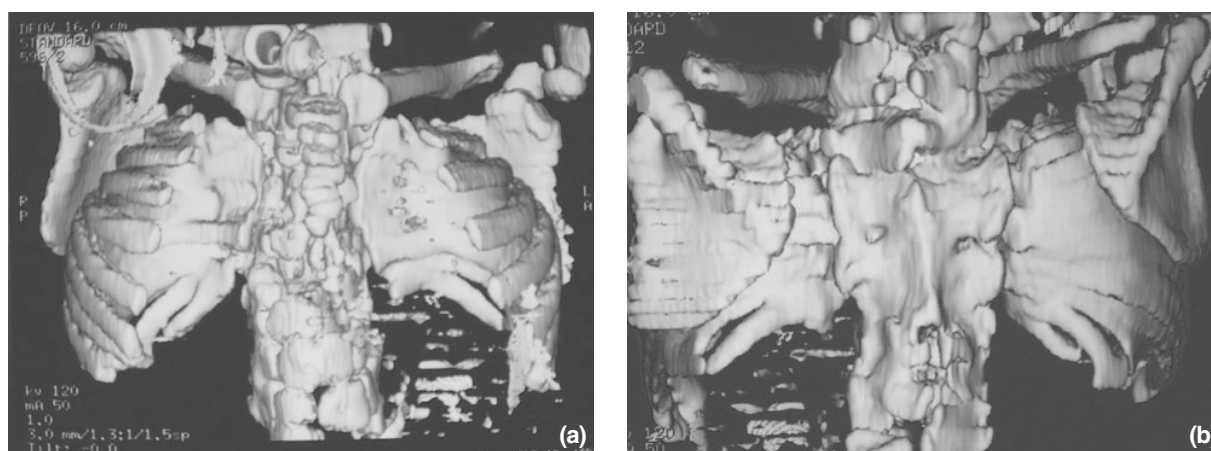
(a) 3D reconstructed CT thorax, anterior view showing small thoracic cage with crab-like appearance. (b) 3D reconstructed CT, posterior view showing symmetrical fusion of the posterior ribs at the costovertebral junctions. No scoliosis was detected.
